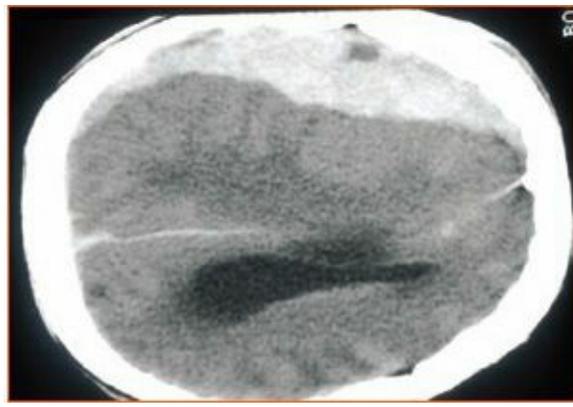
Computed tomographic scan of an isodense subdural hematoma.
